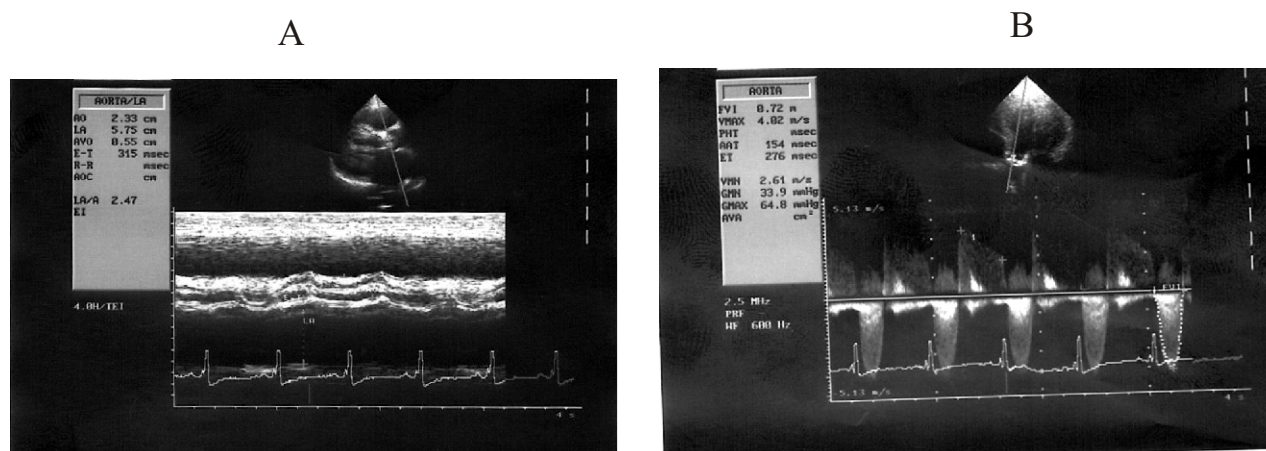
Upper panel (A) is a 2D guided m-Mode echocardiogram showing thickening, fusion and sclerosis of the aortic valve leaflets with aortic box reduced to a slit-like opening in a 45 year old Nigerian woman and lower panel (B) is a continuous wave Doppler from the same patient showing combined aortic regurgitation and stenosis (pressure gradient=64.8mmHg).
